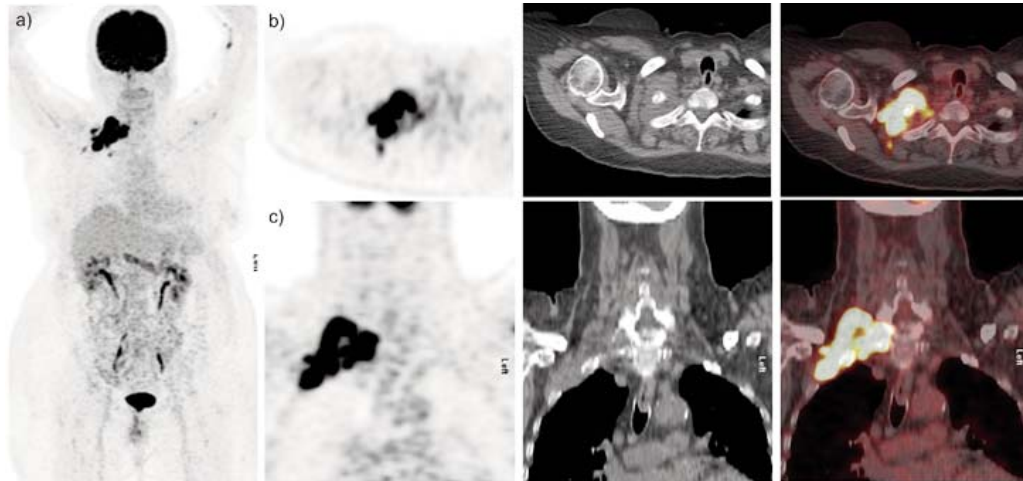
A 54-year-old female, a known case of chronic lymphocytic leukaemia in remission, presented with pain in her right arm and neck with progressive numbness in the right hand. The patient underwent ^{18}F -FDG PET/CT scan, which showed increased tracer accumulation in the right neck and right supraclavicular region in the distribution of C5 to T1 nerve roots of the brachial plexus which was proven to be neurolymphomatosis on nerve biopsy.
